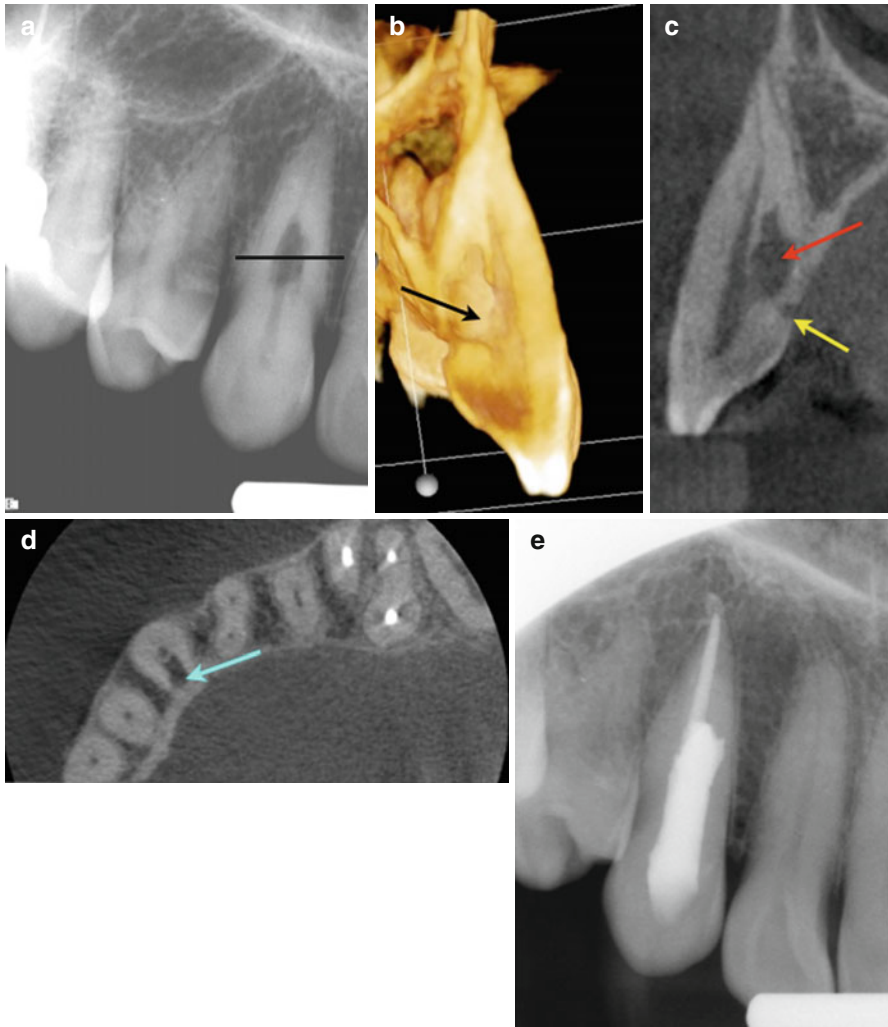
(a) Periapical radiograph of tooth #6. The patient was referred for evaluation and treatment of an internal resorptive defect. The *line* corresponds to the axial section view in (d). (b) 3D reconstruction of the resorptive defect (*black arrow*). (c) Sagittal view of tooth #6 demonstrating the internal resorptive defect (*red arrow*), and confirming that the defect is an external ICR defect with initial entry at the cemento-enamel junction (*yellow arrow*). (d) Axial view demonstrating the ICR nature of the defect. Note in (c, d) that the pulp was not involved. (e) Postoperative radiograph of tooth #6 after root canal therapy and repair of the resorptive defect
